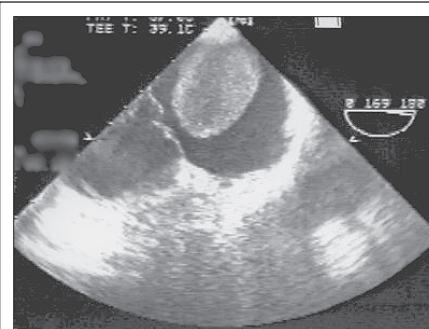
Transesophageal echocardiography in horizontal view: A large mass is seen in the right atrium
